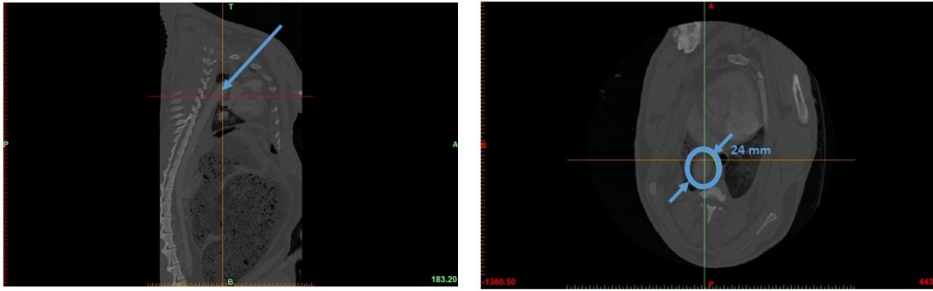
Determining the diameter of the aorta from CT scans
